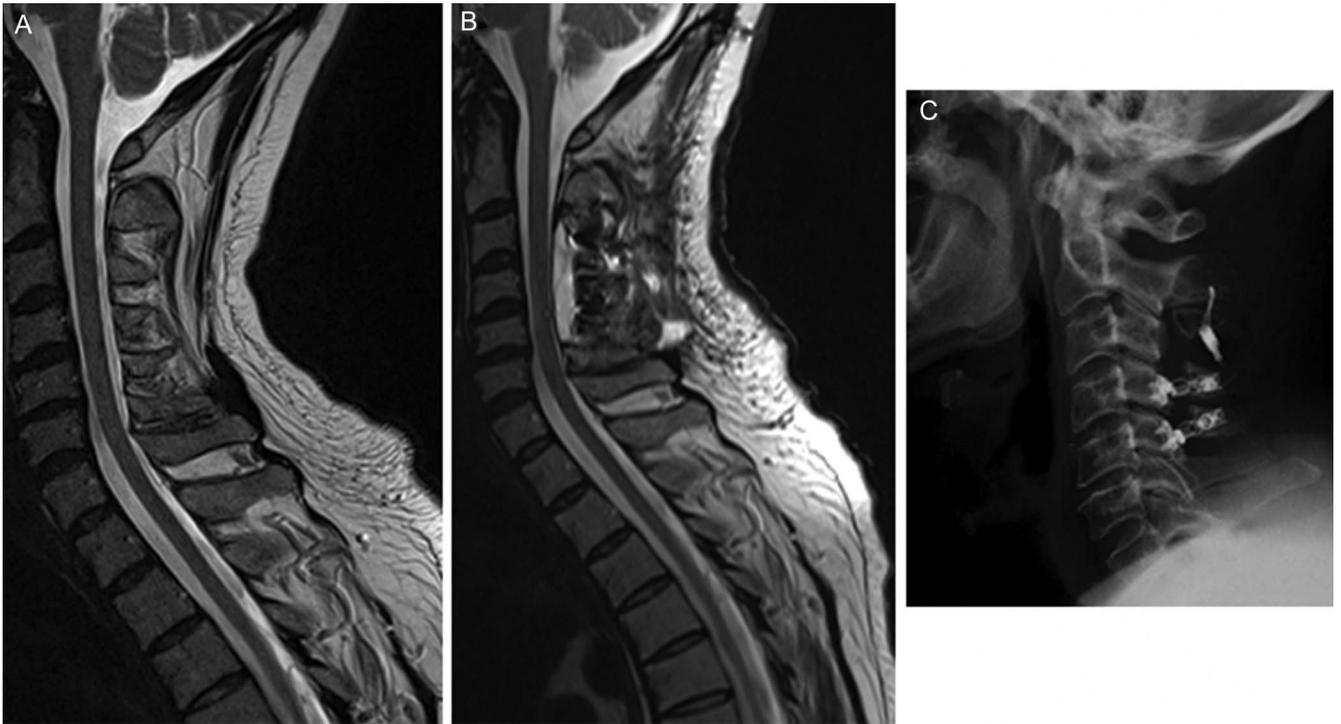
Post-operative kyphosis. Despite care to preserve the facet joints at each level of the dissection, including the rostral and caudal extent of the exposure (C2/3) and (C5/6), the first cervical microinjection patient (trial patient 13) developed a progressive kyphotic deformity. There was no radiographic evidence of myelomalacia or postinjection cord injury. A, a midsagittal preoperative T2-weighted MRI demonstrates a loss of normal cervical lordosis. B, an MRI obtained at 3 months postoperatively demonstrates the development of a kyphotic deformity with draping of the spinal cord over cervical vertebrae. C and D, respectively, demonstrate a midsagittal T2-weighted MRI and lateral plain radiograph obtained at 6 months postoperatively. These demonstrate of the postsurgical kyphotic deformity. MRI, magnetic resonance imaging.
